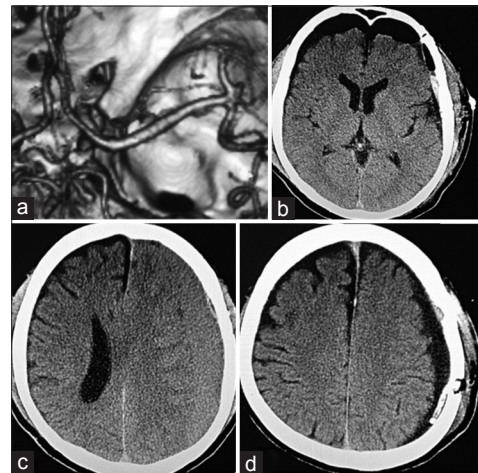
(a) Three-dimensional computed tomography angiogram left middle cerebral artery aneurysm, (b) postoperative computed tomography after clipping, showing dead space with pneumocephalus (bifrontal), (c) follow up computed tomography head at 1 month, large left side chronic subdural hematoma/hygroma compressing ipsilateral ventricle with midline shift, (d) postoperative computed tomography head with complete evacuation of chronic subdural hematoma/hygroma and drain *in situ*
